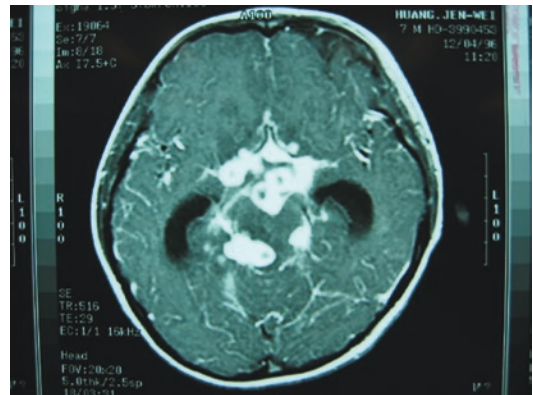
Magnetic resonance imaging of brain performed at the time when impaired visual acuity developed revealed multiple tuberculomas in basal, cerebellopontine angle, prepontine cisterns, brain stem and right temporal lobe, involving optic chiasma with hydrocephalus (transverse T1-weighted image after intravenous contrast enhancement; TR516/TE29) (Reproduced with permission from (Tsai et al. 2004))
